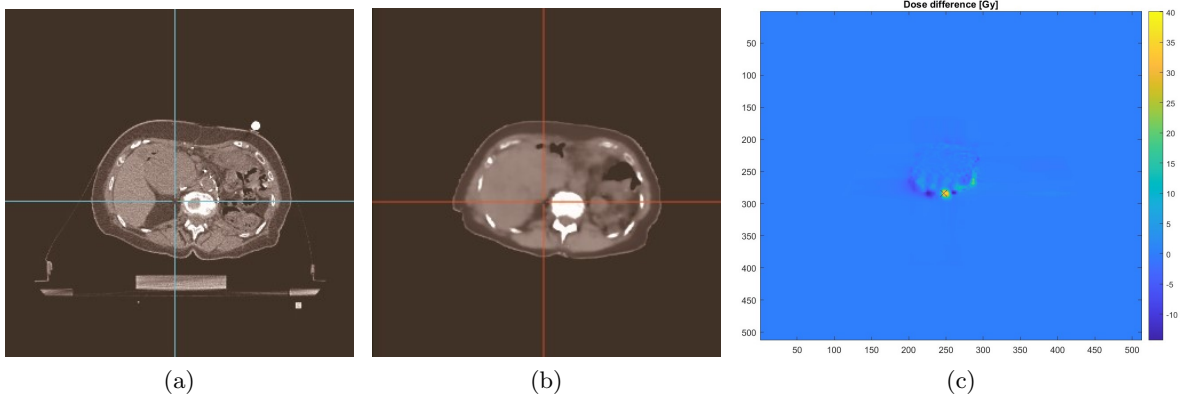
Maximum dose difference point plotted on the CT (a) and on the sCT (b), along with dose difference distribution (c) in the slice corresponding to the maximum dose difference.
